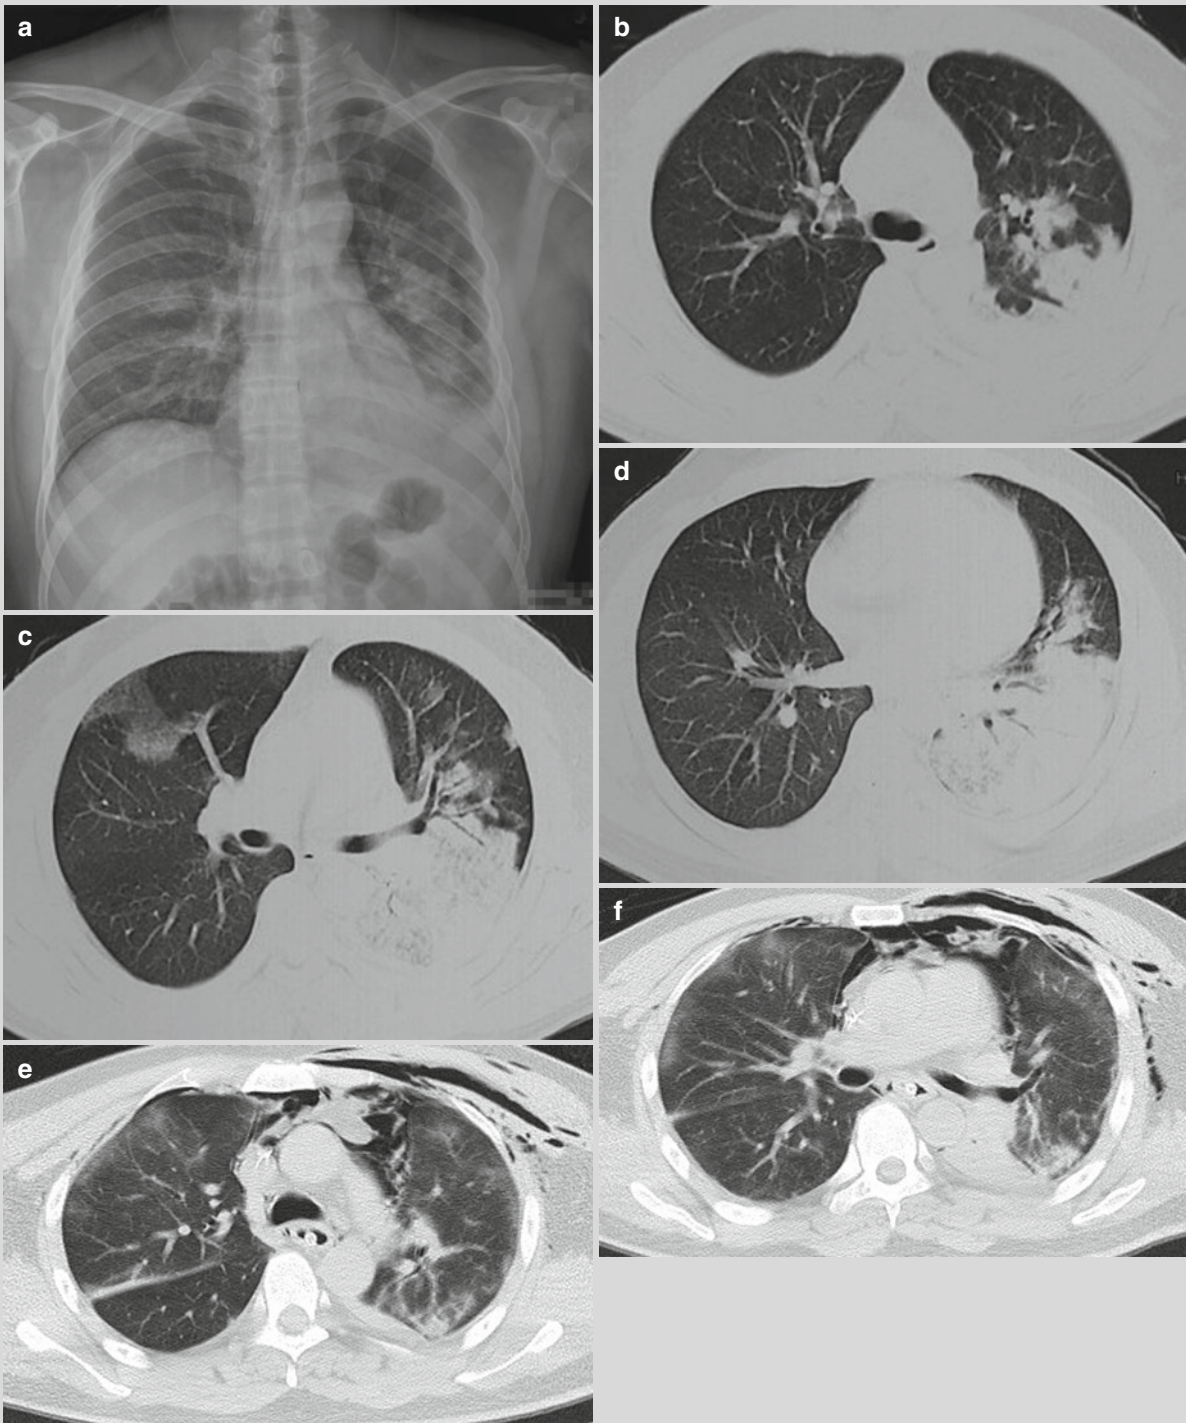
On d 3 after onset, chest X-ray showed large flakes of high density opacity in the left middle and lower lung fields, with poorly defined boundary; flakes of ground glass opacity in the right middle lung field; and blunt left costophrenic angle (a). On d 3, chest CT scan showed irregular flakes of opacity in the apical posterior segment of left upper lung lobe (b). Patches of ground glass opacity in the right middle lung lobe and the left upper lung lobe; large consolidation in the left lower lung lobe (c). Shrinkage of the left lower lung lobe was shown, with large consolidation and air bronchogram inside (d). On d 14, chest CT scan demonstrated flakes of ground glass opacity in both upper lungs; gas opacity in the anterior mediastinum and the thoracic wall (e).
